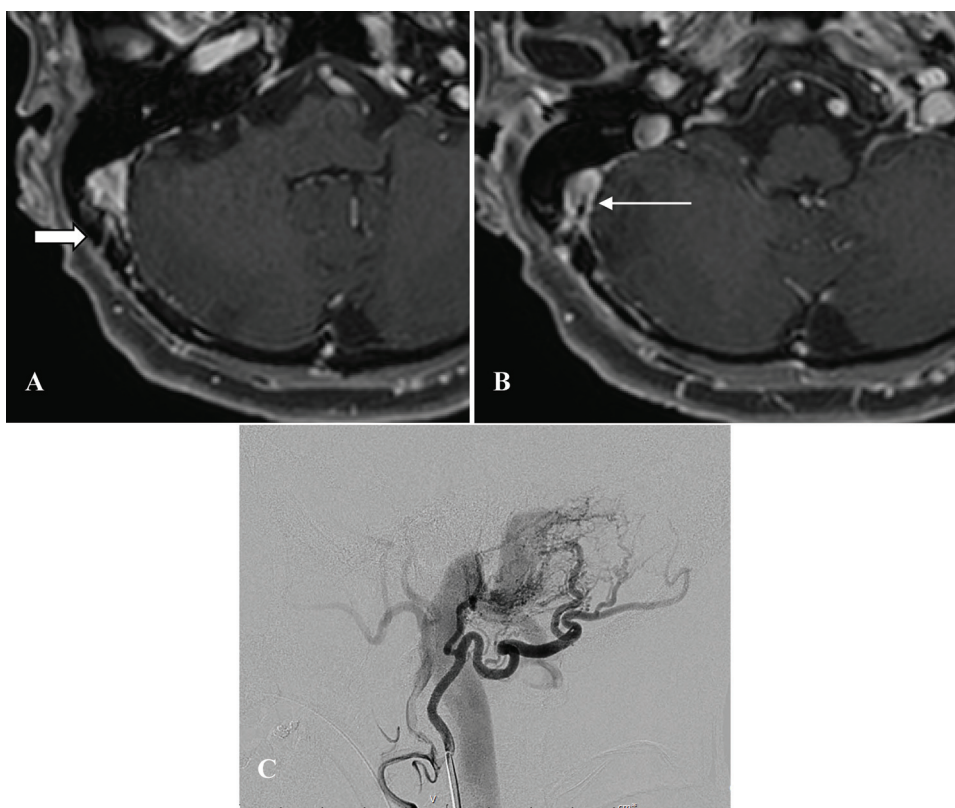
Dural AVF at the right sigmoid sinus. (A, B) Axial 3D contrast-enhanced THRIVE MRI shows transosseous feeding arteries (thick white arrow), low intensity curvilinear structures in dural sinus (thin white arrow) and shaggy sinus at the right sigmoid sinus. (C) DSA reveals benign dural AVF at the right sigmoid sinus.
